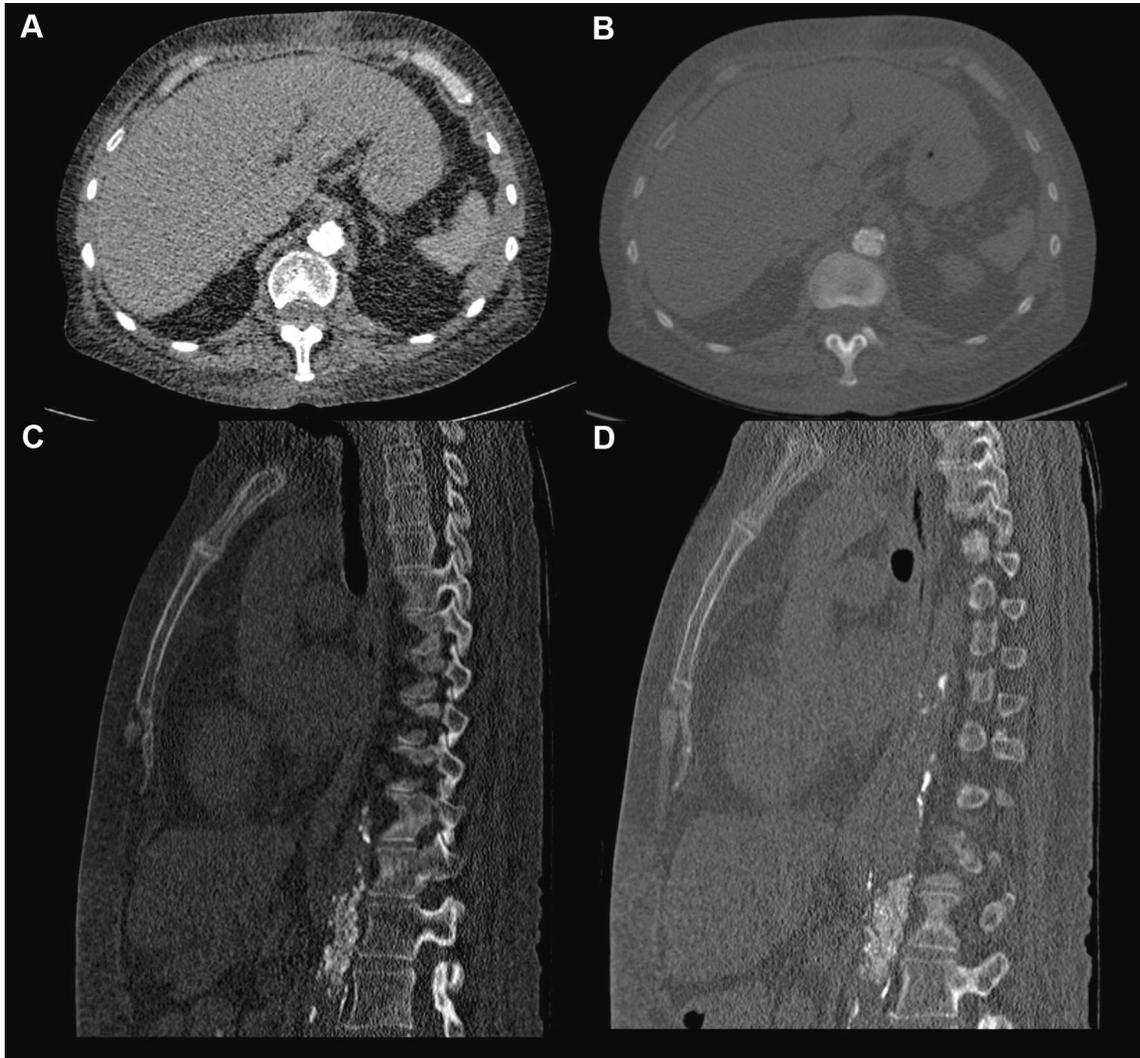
Unenhanced transversal CT images are presented in mediastinal (A) and lung (B) window. Multiplanary reconstructions with sagittal view on aorta in bone (C) and lung window (D) are given.
